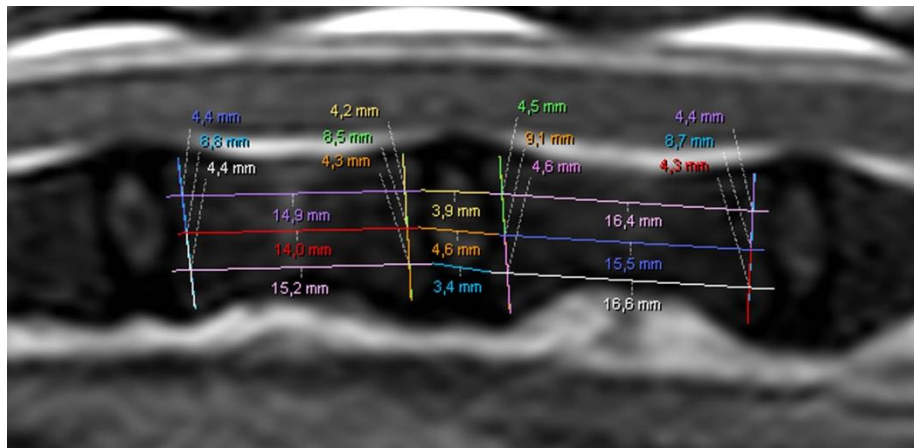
Method for radiographic measurement of disc height (DH) and adjacent vertebral bodies in Philips DICOM Viewer.
